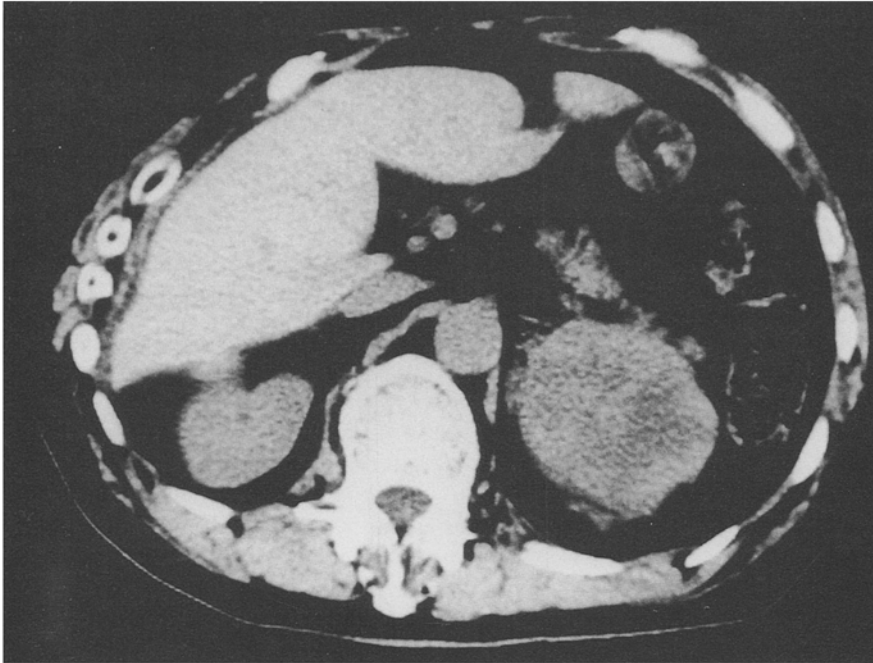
CT scan of case 1 demonstrating an enlarged left adrenal gland with a low density area
